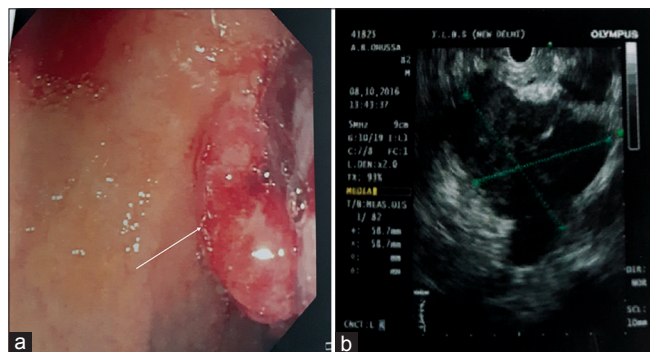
(a) Endoscopic image of polypoidal lesion (white arrow) in D1–D2 junction; (b) endoscopic ultrasound image showing pancreatic head mass
